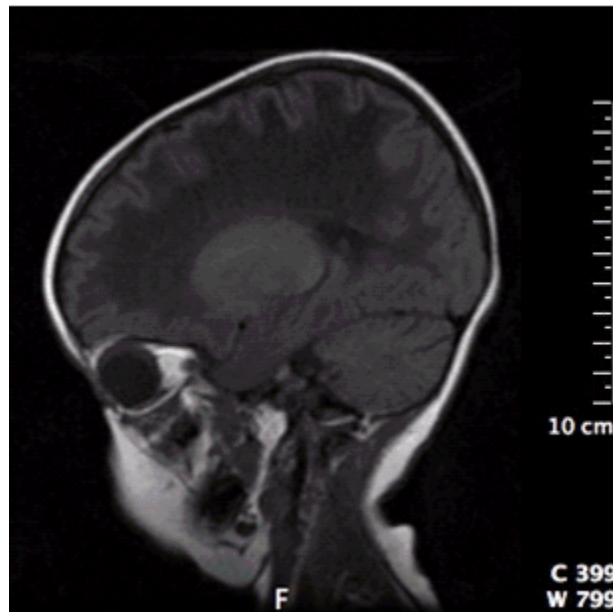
Parasagittal T₁-weighted MRI image of an individual with CACH/VWM shows diffuse hypointensity of the white matter interrupted by a typical meshwork of remaining tissue strands radiating across the abnormal white matter.
